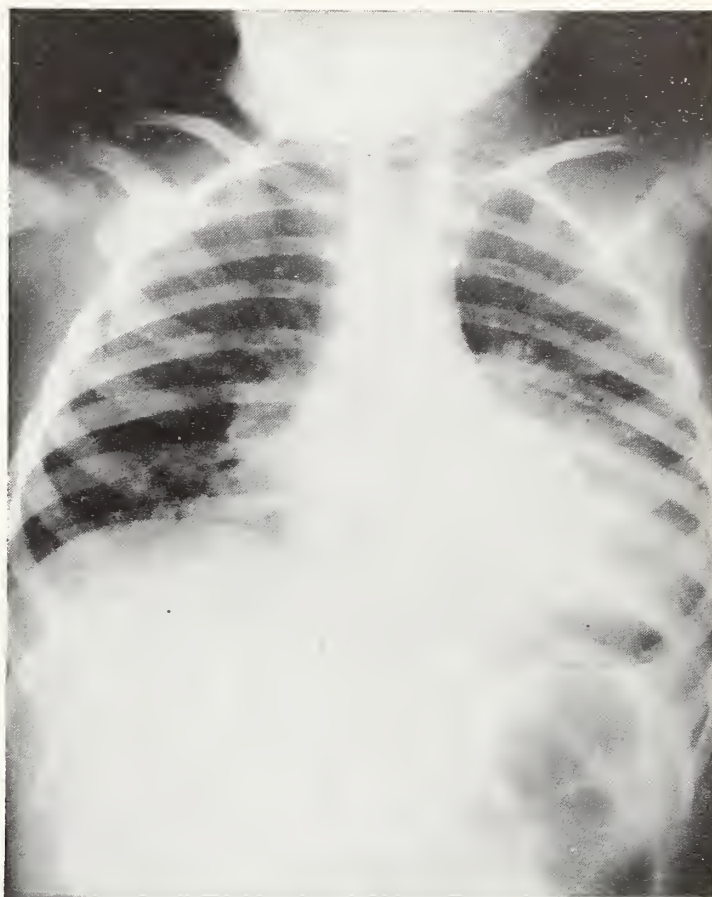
Case 5. Chest radiograph four days after ingestion of liquid red furniture polish.
